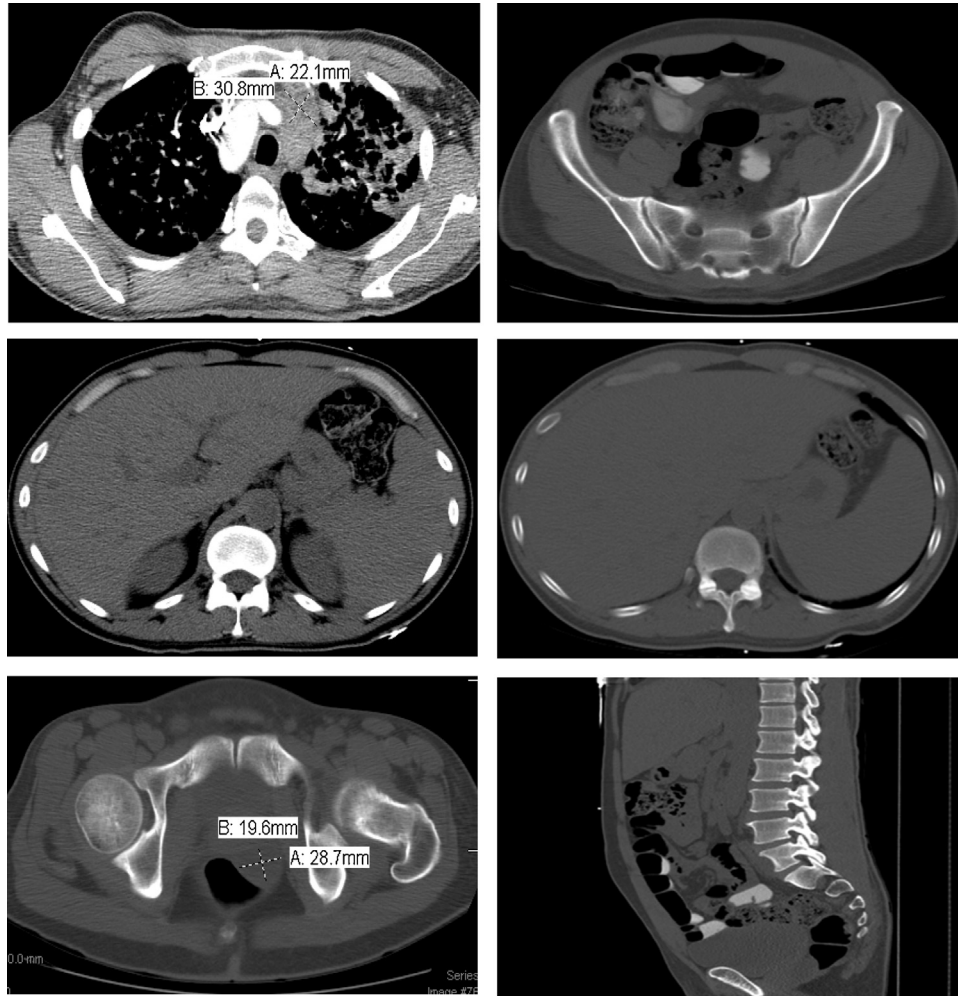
(A) CT chest showing patchy involvement of the lung with nodules, one shown here measuring 3.1 cm in greatest dimension. (B) CT abdomen and pelvis showing multiple low attenuation left sided mesenteric lymph nodes measuring 2.5×2.4 cm suggestive of necrotic lymphadenopathy (C) multiple microabscess of the liver (D) Mild splenomegaly at 12.5 cm (E) Enlarged prostate with heterogeneous low attenuation area with $2.9 \text{ cm} \times 2.0 \text{ cm}$ area of fluid attenuation at the left posterior aspect that appears to arise from the prostate concerning for abscess, axial plane (F) prostatic abscess, sagittal plane.
